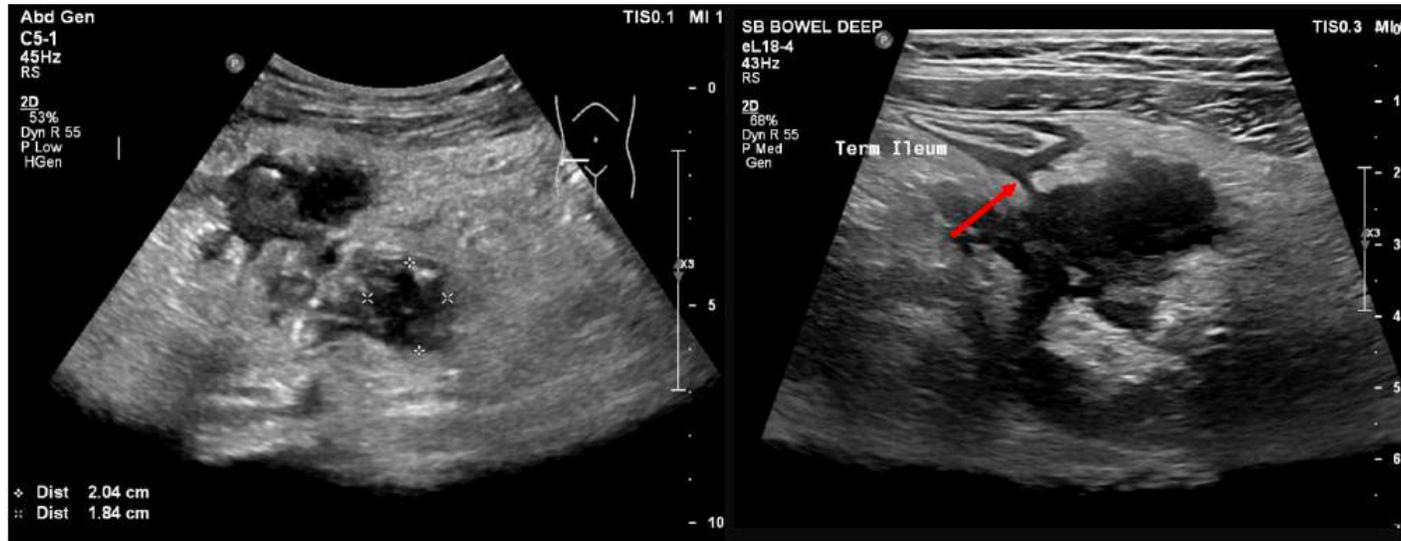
Anastomotic and naive small bowel Crohn's disease strictures on intestinal ultrasound defined by the combination of bowel wall, luminal narrowing, and pre-stenotic dilatation
